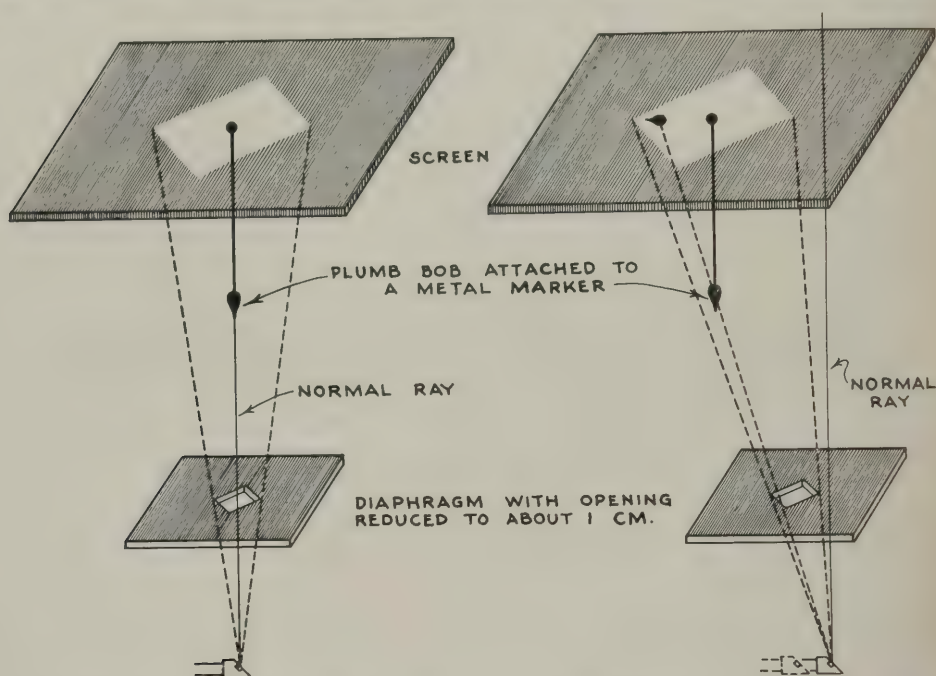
Showing the positions of shadow of plumb bob on fluorescent screen when X-ray tube is properly centered, and when off center
